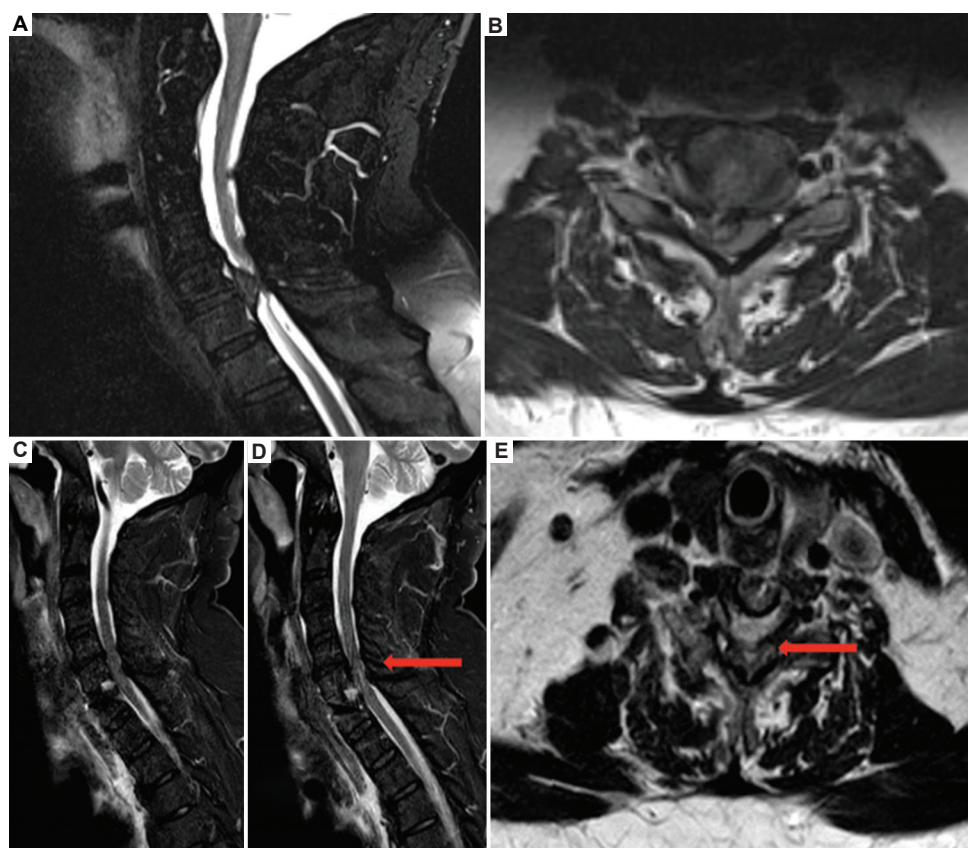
Pre-operative magnetic resonance imaging (MRI) scans showing sagittal (A) and axial views (B), demonstrating a herniated disc with significant spinal cord compression. Postoperatively, urgent MRI scans in sagittal (C, D) and axial views (E) reveal the characteristic T2 hyperintensity of white cord syndrome, indicating spinal cord edema without residual mechanical compression (red arrow).
